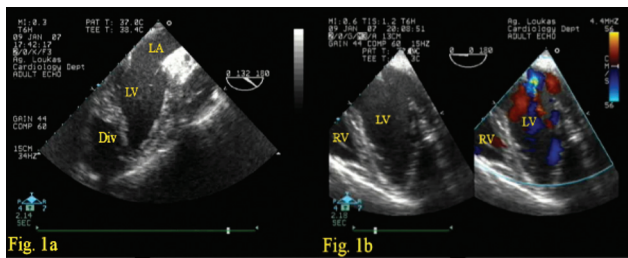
Intraoperative transesophageal echocardiography. A, Midesophageal long-axis prerepair view showing the apical diverticulum (Div) with narrow communication with the major left ventricular (LV) cavity. B, Four-chamber postrepair view showing restored LV volume and geometry. LA indicates left atrium; RV, right ventricle.
